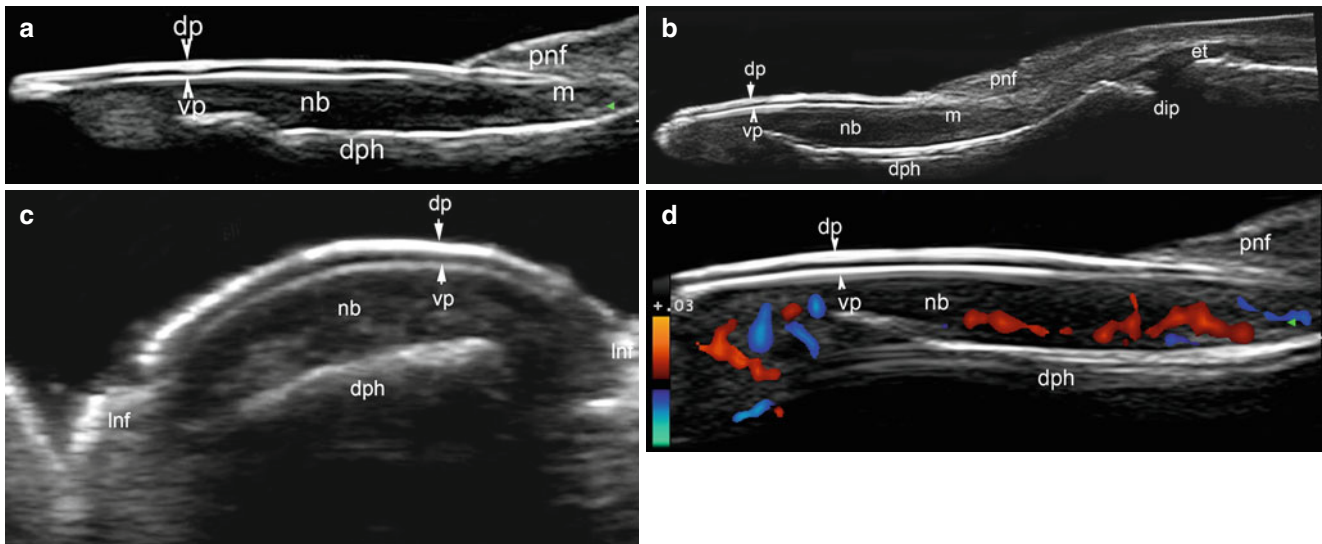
(a–d) Nail anatomy. (a) Ultrasound of the nail unit (longitudinal view). (b) Ultrasound of the nail unit (longitudinal extended panoramic view) including the insertion of the extensor tendon (*et*) and the distal interphalangeal joint (*dip*). (c) Ultrasound of the nail unit (transverse view). Note lateral nail folds (*lnf*). (d) Color Doppler
